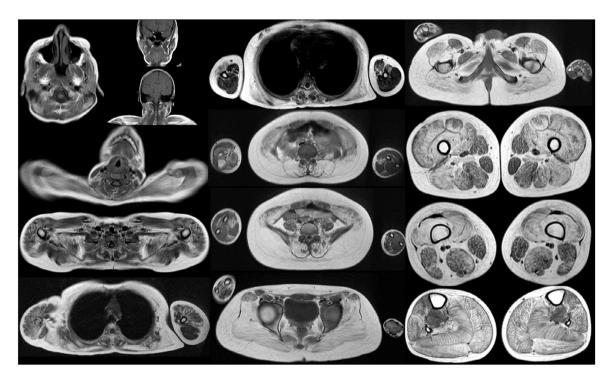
Whole-body muscle MRI in a patient with LGMDR9 linked to FKRP (Axial T1 images, Imaging Department, Raymond-Poincaré Hospital, AP-HP 2018). Note the symmetrical pattern of muscle fatty infiltration, affecting the scapular and pelvic girdles as well as the spinal muscles. In the thighs, both anterior and posterior compartments are involved; note the sparing (with relative hypertrophy) of the gracilis. In the legs, there is diffuse involvement of all muscles, with the medial gastrocnemius being slightly more affected than the lateral, and marked involvement of the fibular and tibialis anterior muscles.
